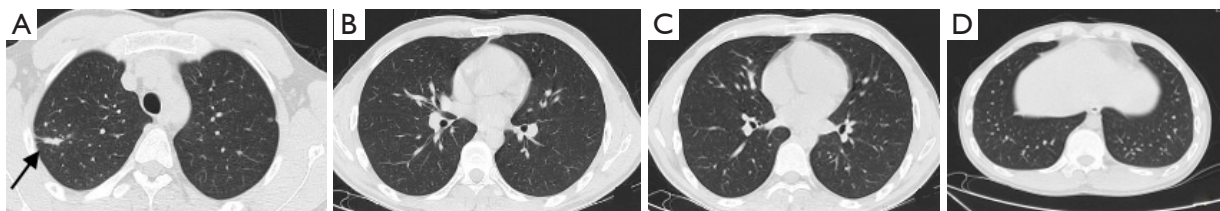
Case 1, initial chest CT showed partially oval lesion with a ring of consolidation on the anterior surface and a central cavity with surrounding consolidation in RUL (A, black arrow), without any other lesions (B-D). CT, computed tomography; RUL, right upper lobe.
